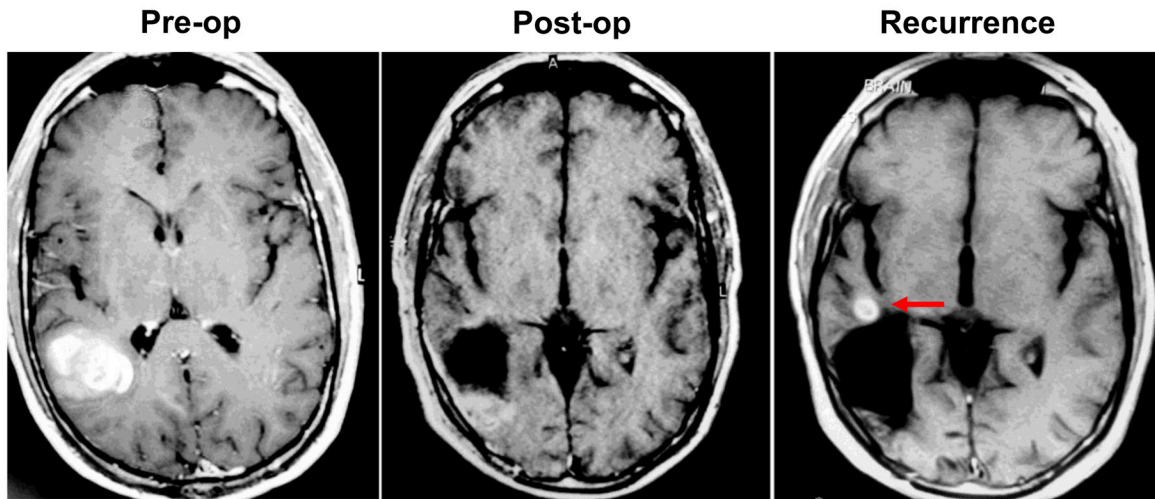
Glioblastoma images. Contrast enhanced magnetic resonance imaging of glioblastoma before surgical resection (pre-op), after surgical resection (post-op), and of local recurrence within 2 cm of the original tumor border (indicated by red arrow) 10 months later. Figure adapted from [5] with permission.
